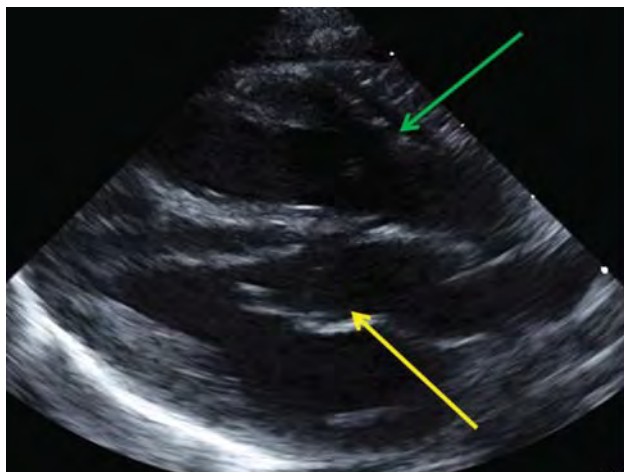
Echocardiogram: parasternal long-axis view displaying parallel outflow tracts, with the pulmonary artery arising posteriorly from the left ventricle (yellow arrow), and the aorta arising anteriorly from the right ventricle (green arrow). Note the fibrous continuity between the open mitral valve and the closed pulmonary valve.
